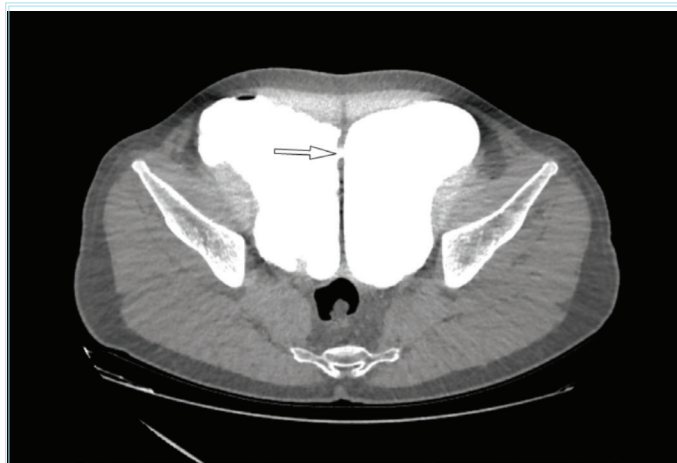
Computed tomography image demonstrating the narrow neck (arrow) between the bladder lumen on the right and the diverticulum on the left
